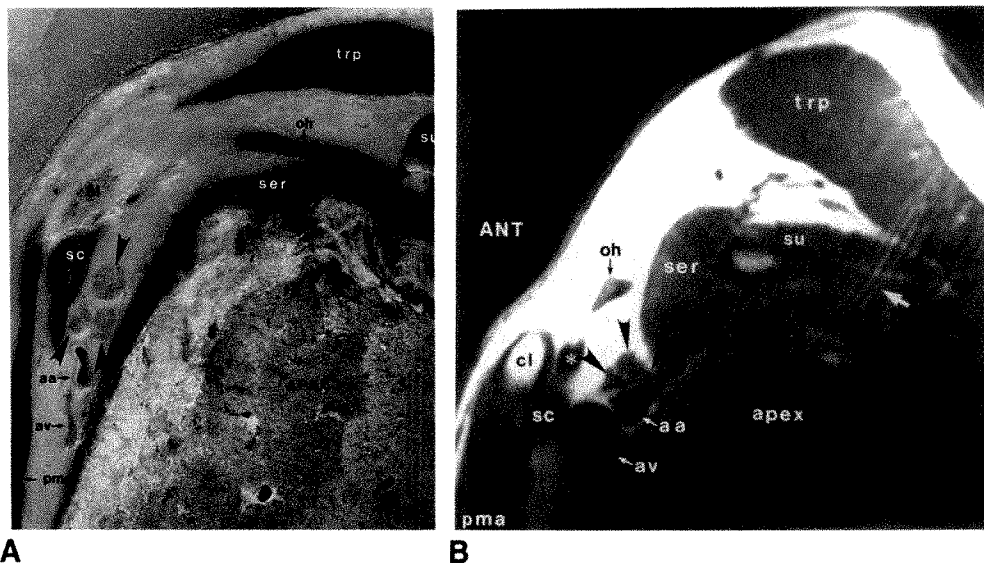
Axial MR images (TR = 600 msec, TE = 25 msec) through medial (superior, A) and lateral (inferior, B) portions of the brachial plexus. Arrowheads = brachial plexus; curved black arrows = small lymph nodes; large white arrow = ghosting artifact caused by blood flow in a vein. See key for abbreviations.
